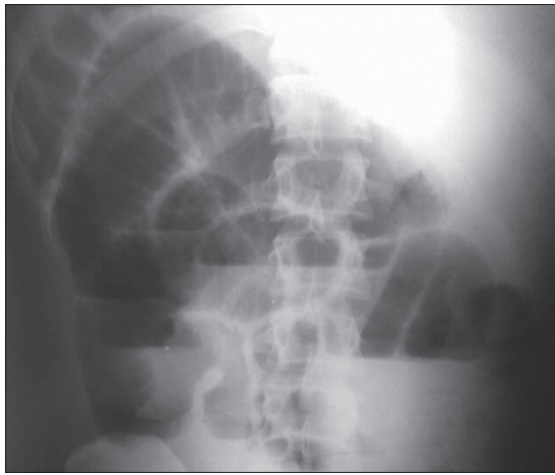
Plain X-ray showing small bowel obstruction
